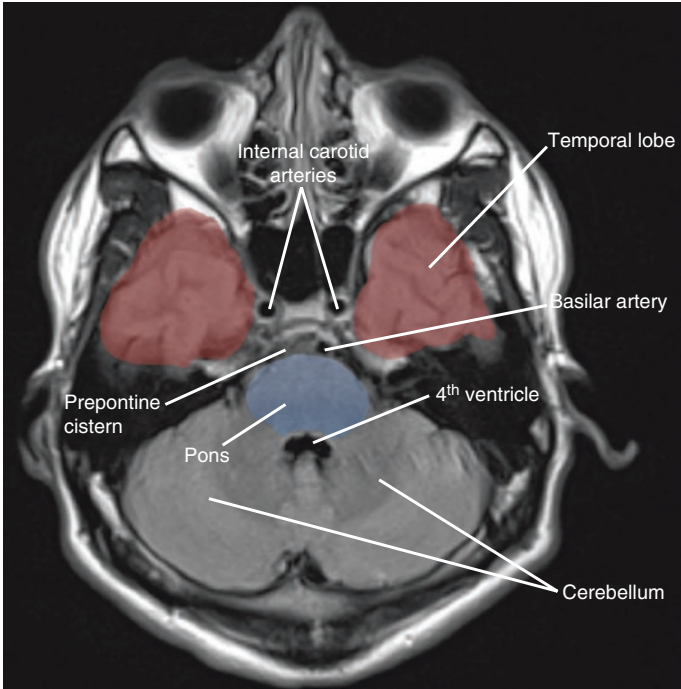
Pons and posterior fossa (Flair sequence MRI brain)
